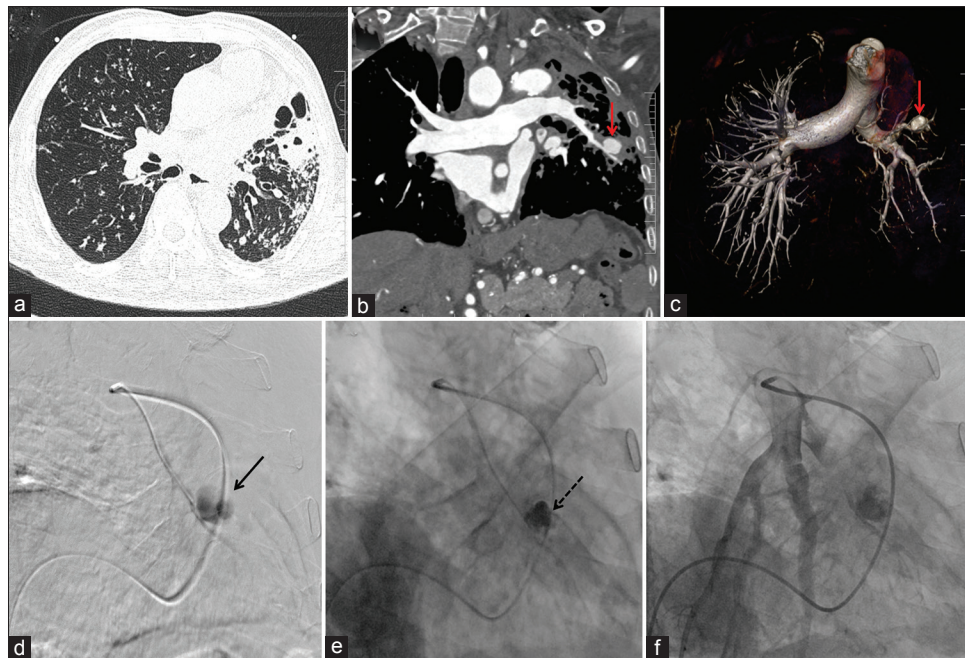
Axial section of high-resolution computed tomography chest (a) in lung window showing subsegmental areas of cavitary consolidation in the left lingula and left lower lobe with multiple discrete and confluent centrilobular nodules in visualized bilateral lung fields, many of them showing tree in bud appearance. Coronal reformatted section of contrast enhanced computed tomography chest (b) showing 15 mm × 13 mm sized pulmonary artery pseudoaneurysm noted arising from anteromedial basal segmental branch of the left pulmonary artery (red arrow). Three-dimensional volume-rendered image of computed tomography pulmonary angiography (c) showing pulmonary pseudoaneurysm (red arrow). Right anterior oblique projection of catheter pulmonary angiography (d) selective injection of contrast after cannulation of segmental branch showing opacification of pseudoaneurysm. Right anterior projection fluoroscopic image (e) showing glue injection in pseudoaneurysm (dashed black arrow). Postglue embolization anteroposterior projection of catheter angiography (f) showing glue cast in pseudoaneurysm with normal opacification of rest of the left descending pulmonary artery
